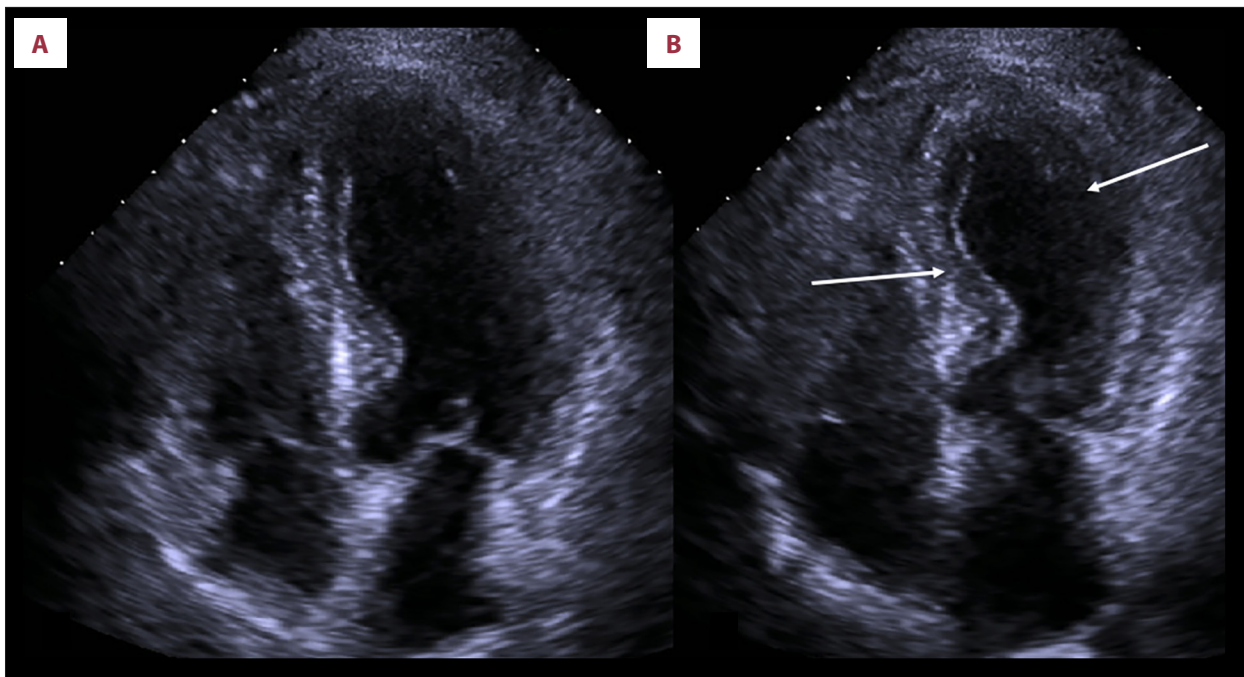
Takotsubo cardiomyopathy event in 2013: transthoracic echocardiogram with apical 4-chamber view; diastole (A), and systole (B). The arrows indicate akinetic inferoseptal and mid-distal anterolateral walls during systole.
